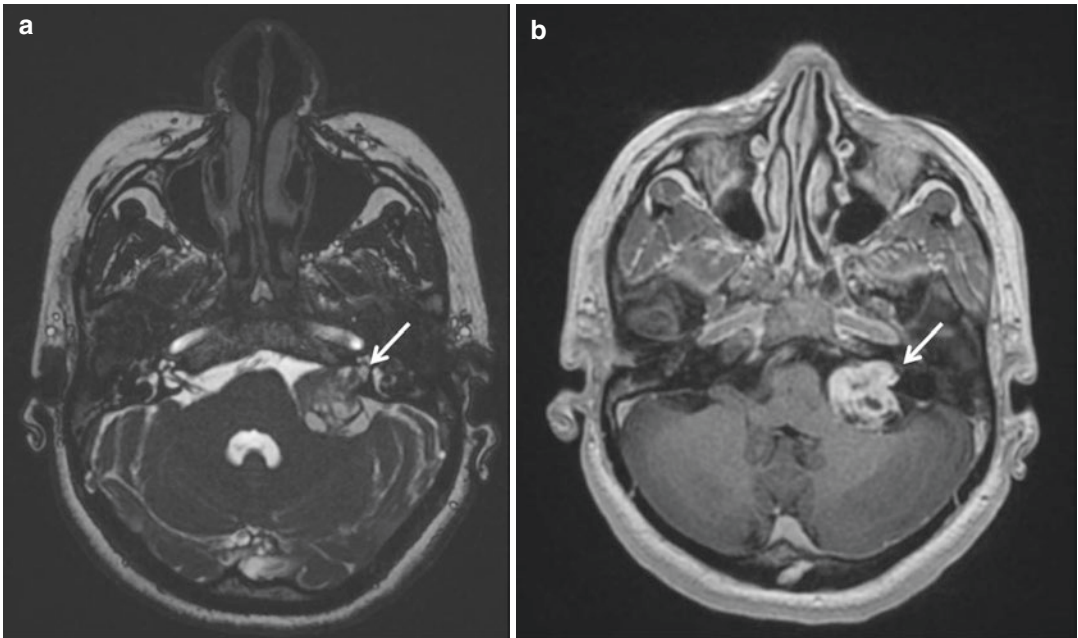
Forty-seven years old woman with NF type 2. A vestibular schwannoma is seen on transverse gradient echo T2W (a) and postcontrast T1W (b) brain MR images
